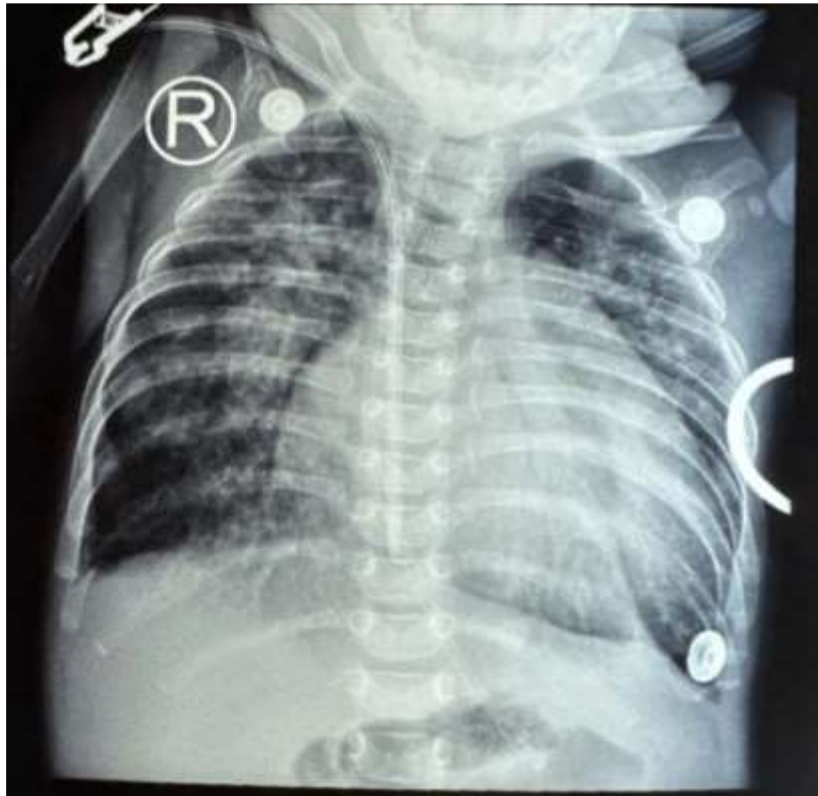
Chest x-ray revealed cardiomegaly, lung infiltrates, and lung oedema
